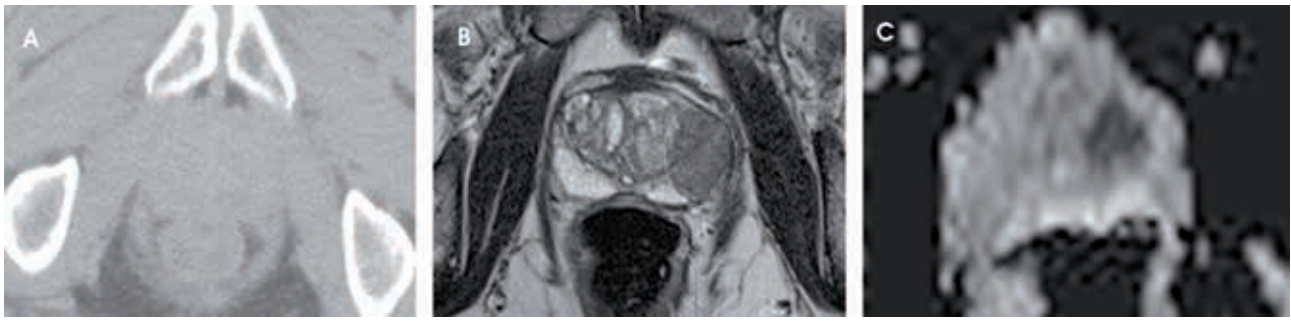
A 75-year old man with Gleason 4+5 prostate cancer on the left side of the prostate. On axial computed tomography (a), the prostate is homogeneously grey and the tumour cannot be demonstrated. The prostate contour is difficult to discriminate from the rectum and pelvic musculature. With magnetic resonance imaging, on the morphological T2-weighted images (b) at the same level as (a) the prostatic anatomy is depicted and the high grade prostate cancer is visible laterally in the left prostate half as a homogeneously low-signal intensity area (white oval). On diffusion-weighted images the tumour typically shows low signal intensity on the apparent diffusion coefficient map (c).
